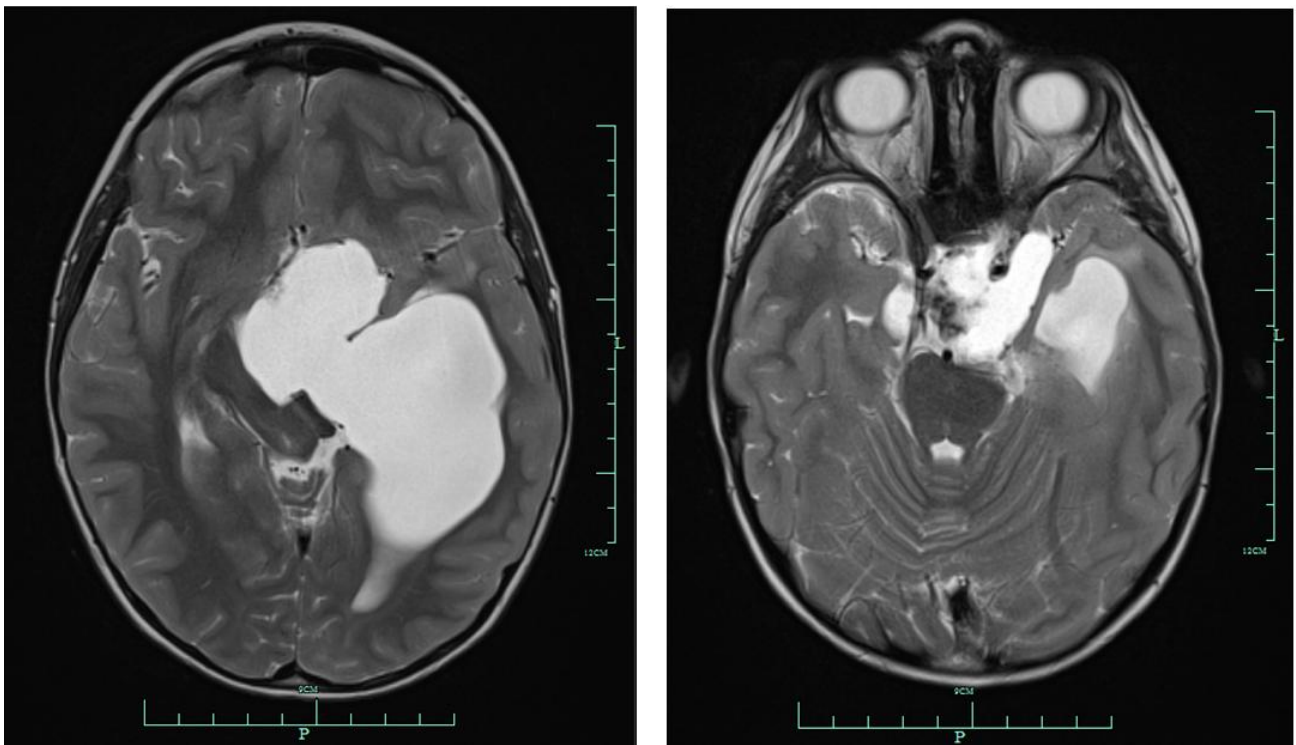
a, 1.1.b MR image
